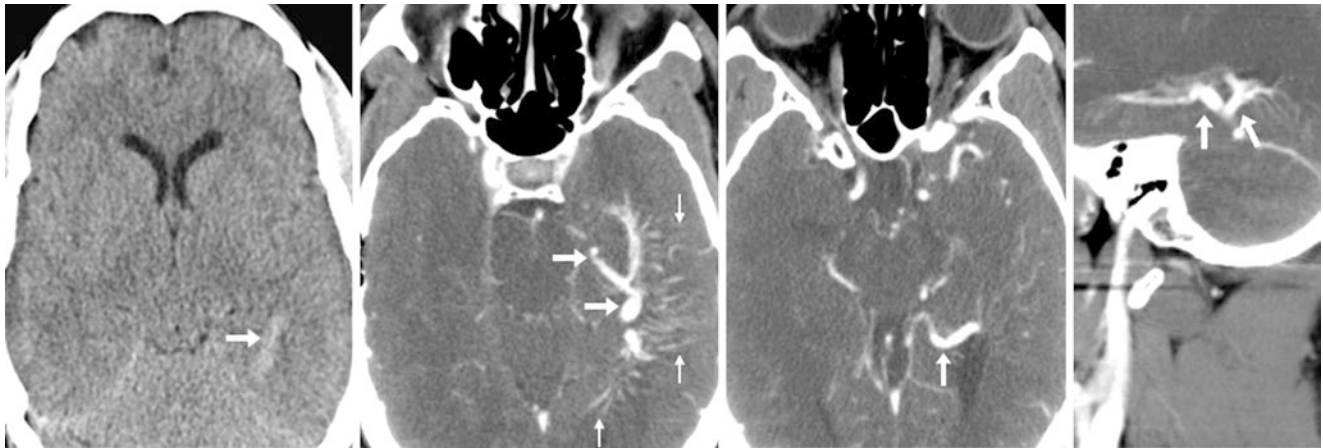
DVA: holoheemispheric variant. A 47 year old had a non-contrast neck CT (*left*) that showed a large vascular-appearing structure within the left temporal lobe that was mildly hyperdense (*arrows*). On postcontrast axial (*left middle and right middle*) and sagittal (*right*)
